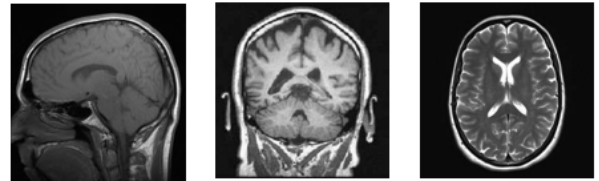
Sample of brain Magnetic Resonance Imaging (MRI) dataset.
